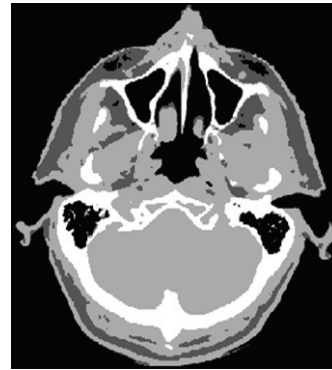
Segmentation of the CT image identified brain, bone, sinus and connective tissue.
